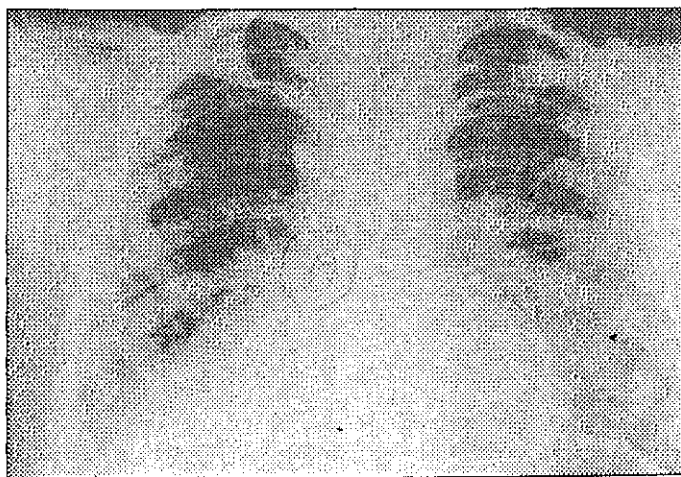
Chest radiograph (at admission) showing a radio-opaque foreign body in the right lower lobe segment and a collapsed and fibrosed lower lobe.
